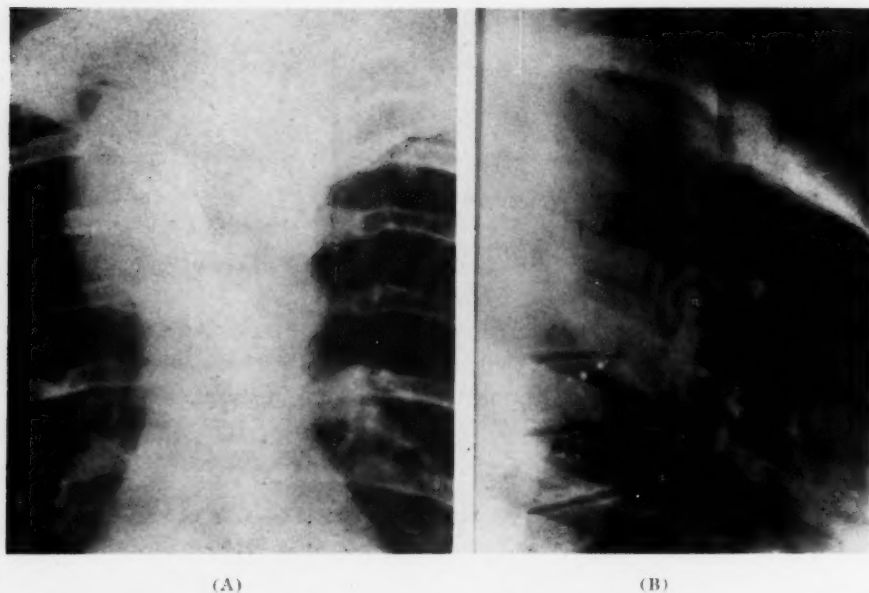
(A) Anteroposterior roentgenogram showing the extent of the tumor mass. (B) Lateral roentgenogram showing the tumor mass and its relation to the air-filled trachea and the esophagus containing barium mixture.
